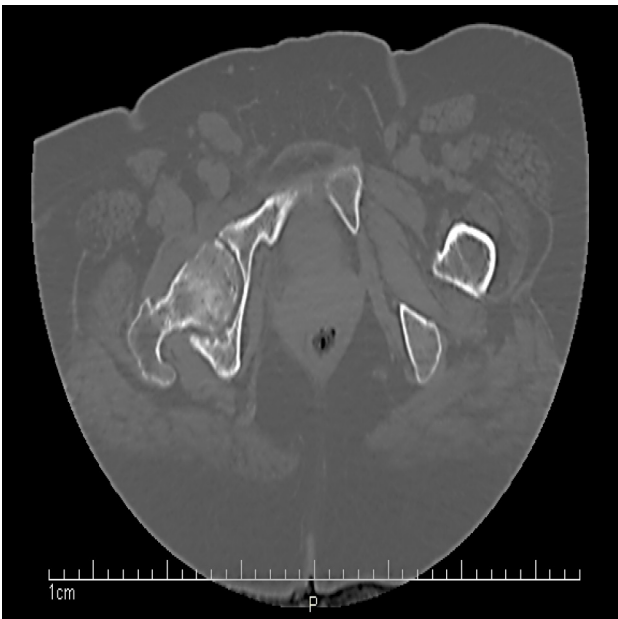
Axial CT scan of the pelvis without contrast: resorption of the left femoral head with advanced degenerative changes
